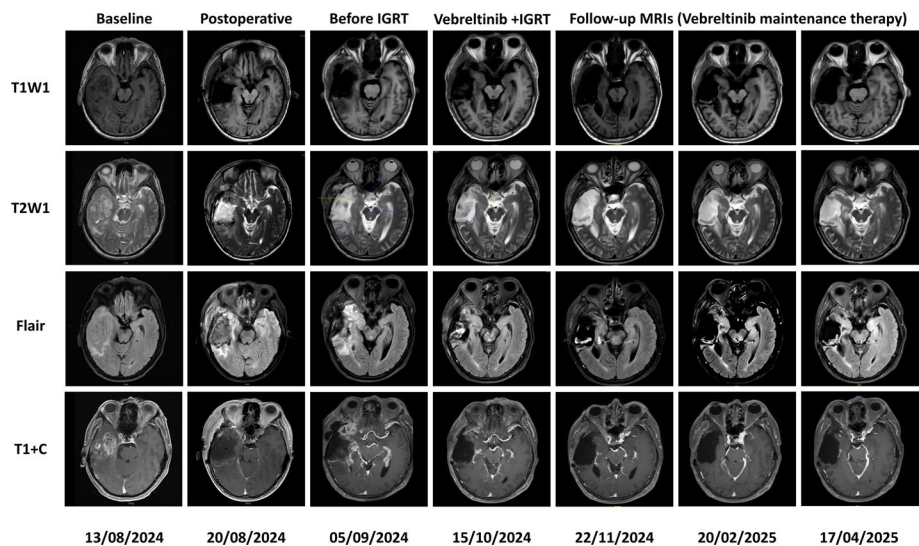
Dynamic MR image during the clinical course. T1 + C, contrast-enhanced T1-weighted image; T1WI, T1-weighted image; T2WI, T2-weighted image; IGRT, image-guided radiotherapy
